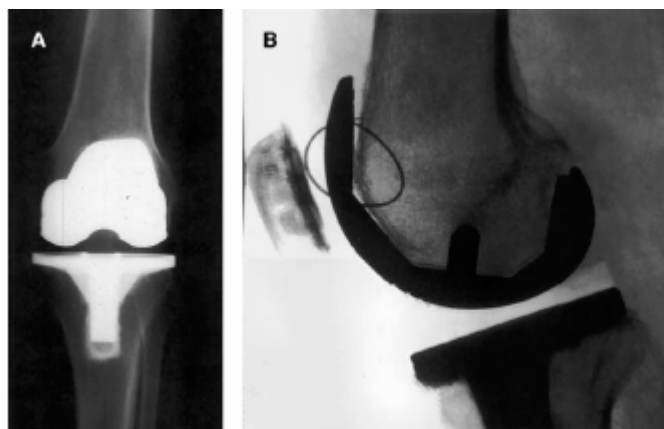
(A) Anterior-posterior radiograph of a patient with a painful knee arthroplasty in apparently good alignment. (B) Lateral fluoroscopic view of an uncemented femoral component of a painful knee arthroplasty (Fehring and McAvoy 1996).
